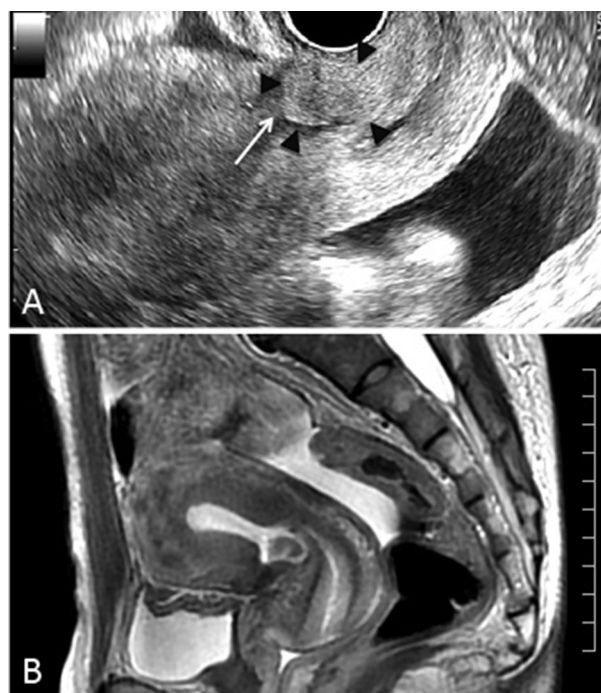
(A) Ultrasound image before surgery. Black arrowheads indicate the solid mass (20 mm × 23 mm) at the foot of the cesarean section scar (white arrow). (B) Preoperative sagittal T2-weighted magnetic resonance image.
